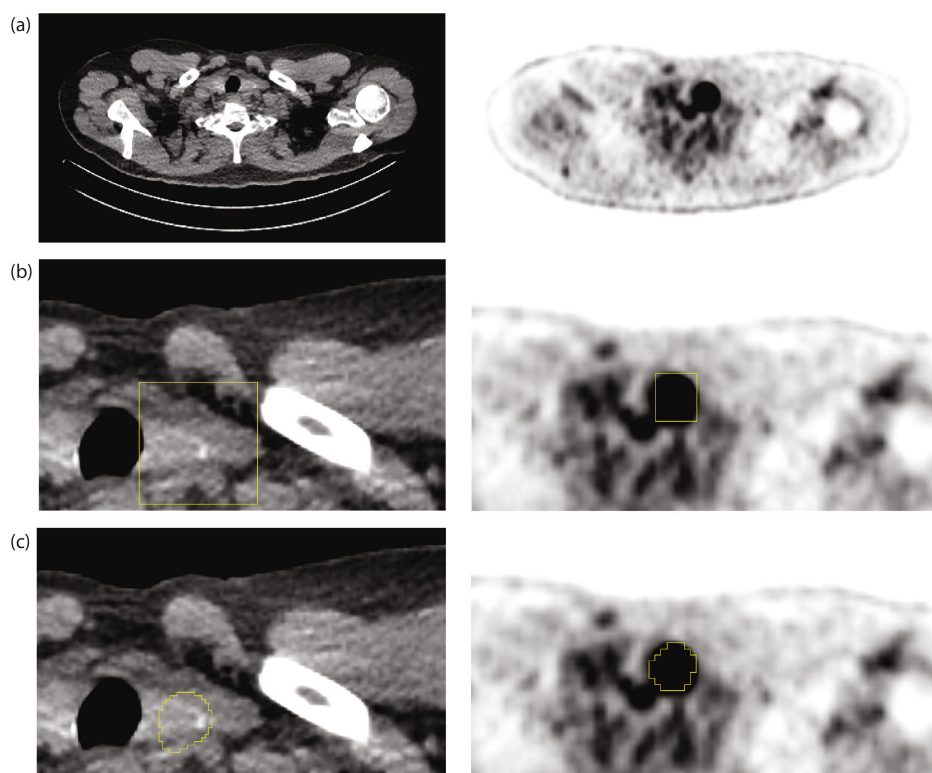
An example of (a) low dose CT and CT-based attenuation correction ^{18}F -FDG PET scans showing (b) the cubical regions of interest (CROIs) and (c) the volumetric segmentations.
